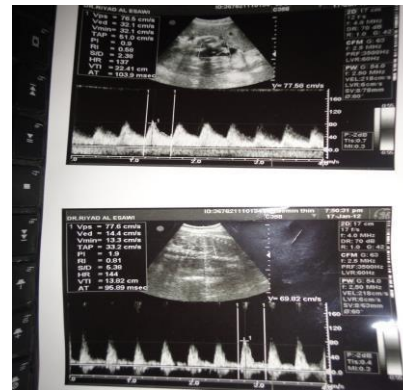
Doppler wave forms of AU (above) & Ao (below) at 37 weeks of gestation
